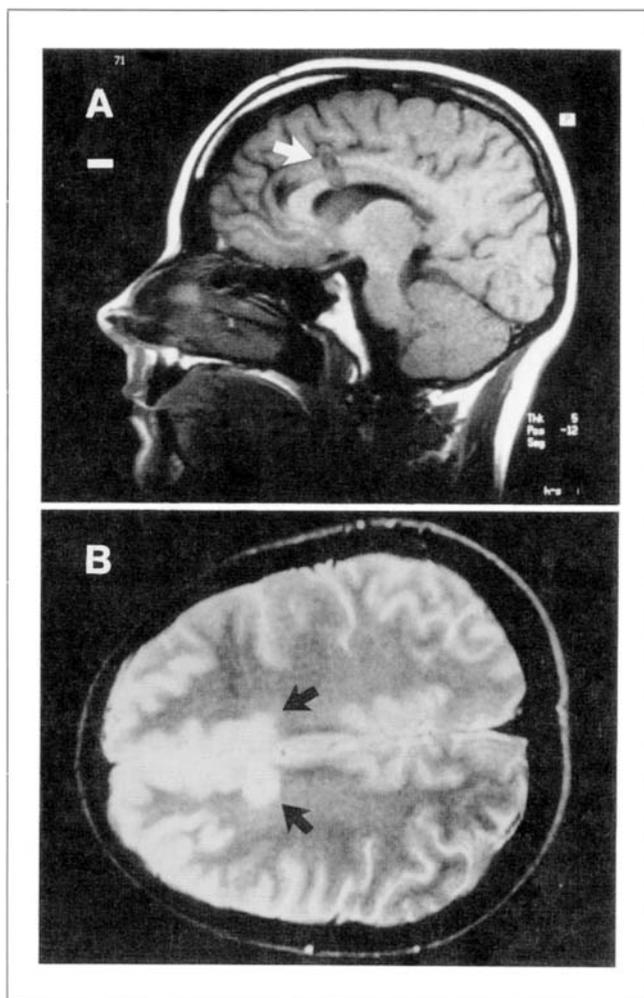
MRI scan of the patient after stereotactic, bilateral anterior cingulotomy. (A) Parasagittal section demonstrating lesion extent and location (arrow). (B) Axial section showing bilateral cylindrical lesions within the anterior cingulate cortex (arrows). Bar = 10 mm.
